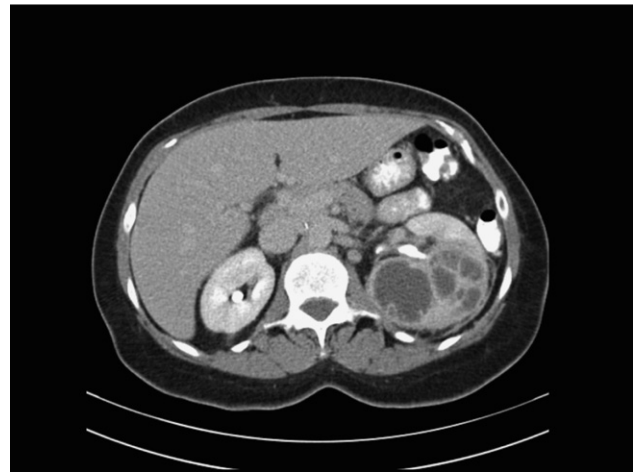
Computed tomography scan of left kidney shows xanthogranulomatous pyelonephritis with renal enlargement, loss of cortical sharpness with infiltration of Gerota's fascia, staghorn calculus fragment, areas of hypodensity, and cystic regions.
